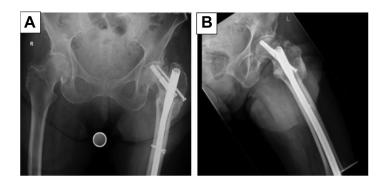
(A) Anteroposterior (AP) and (B) lateral radiographs of a left hip that underwent previous cephalomedullary nailing for left hip fracture. Notice the reverse Z-phenomenon (inferior lag screw migrated medially cutting through the femoral head and the superior lag screw).
